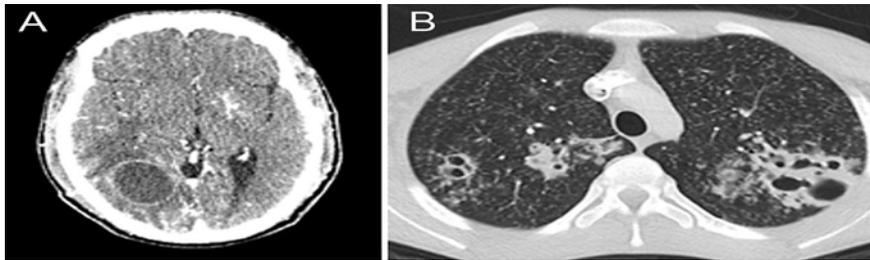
Axial CT scan of the lung shows a miliary nodular infiltrate and multiple cavities in both pulmonary lobes.
